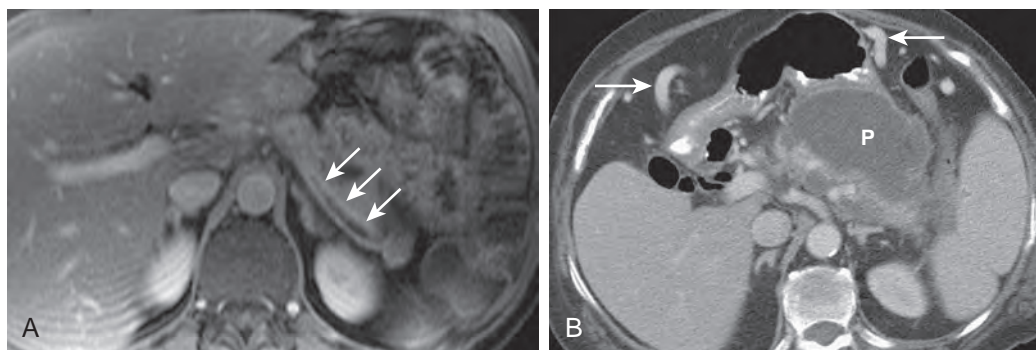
Splenic vein thrombosis. A. Axial enhanced T1-weighted fat-suppressed spoiled gradient-echo MR image shows low signal intensity thrombus (arrows) in the splenic vein. B. Axial contrast-enhanced MDCT image from another patient shows pancreatic pseudocyst (P) and the presence of collateral vessels (arrows), suggesting splenic vein occlusion. (A from Miller FH, Keppke AL, Dalal K, et al: MRI of pancreatitis and its complications: Part 1, acute pancreatitis. *AJR Am J Roentgenol* 183:1637–1644, 2004. Reprinted with permission from the American Journal of Roentgenology.)
